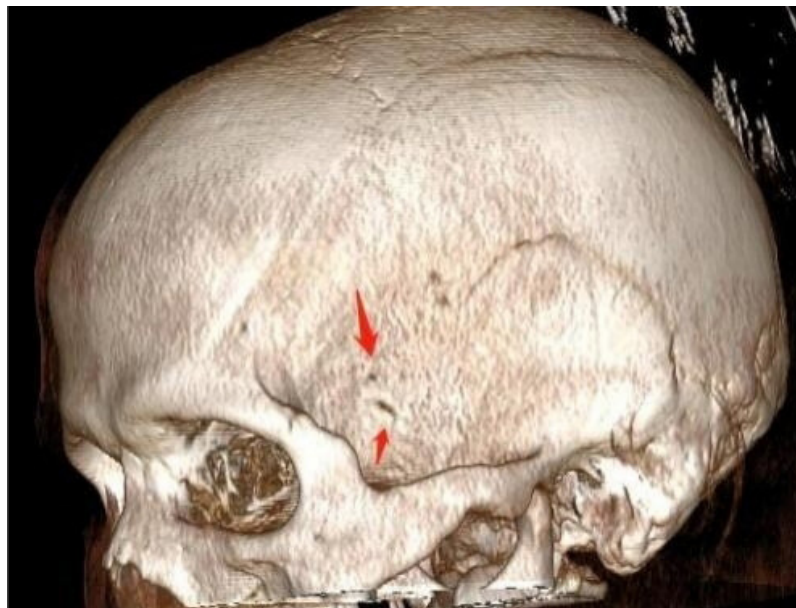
3D reconstruction CT scan from September 23, 2020. Arrow indicates the congenital cranial vascular foramen
